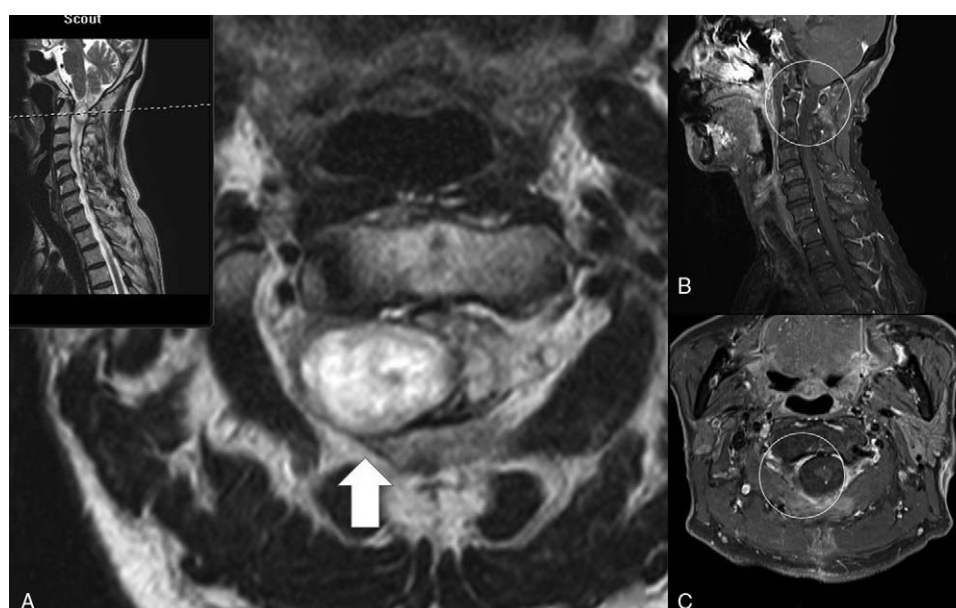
(A) Preoperative. (B and C) Postoperative. (A) Preoperative cervical T2-weighted magnetic resonance imaging (MRI) shows a right intradural-extramedullary mass with myelopathy at the C1–2 level (arrow). (B and C) Postoperative cervical MRI shows a complete removal of the mass after surgery (circle).
